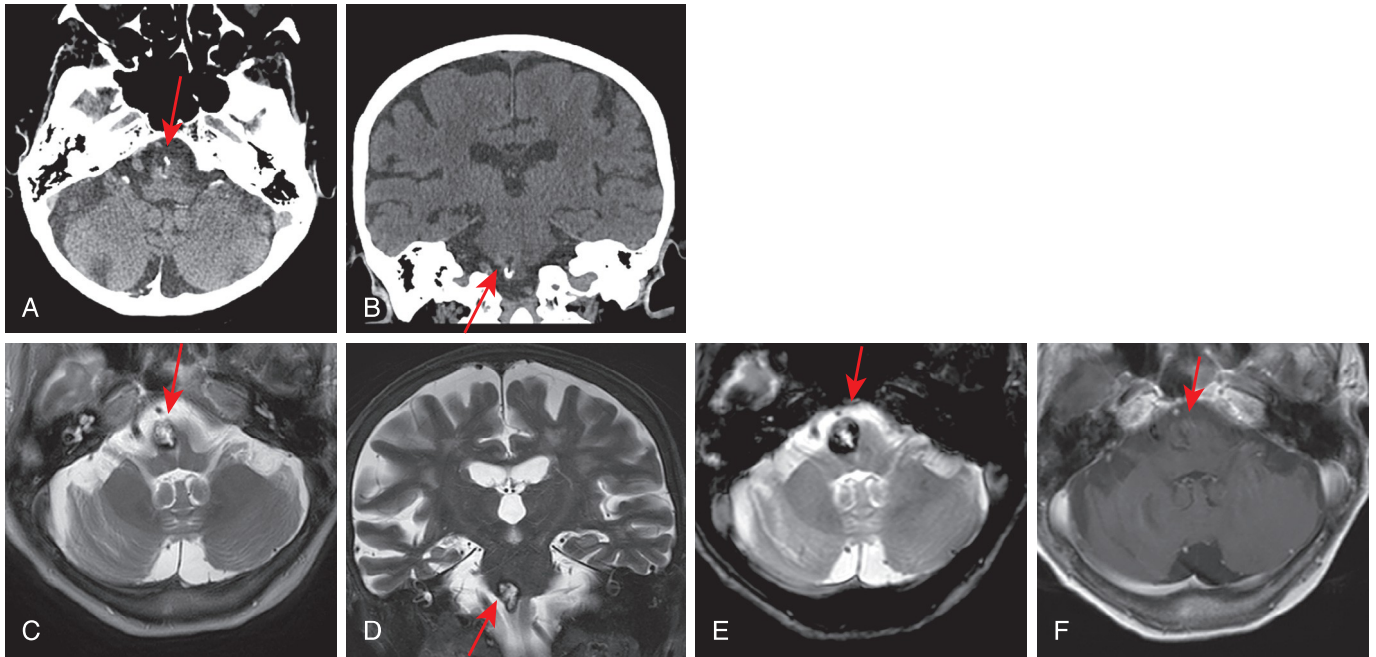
Cavernous malformation. An 84-year-old woman presented with altered mental status. Axial (A) and coronal (B) noncontrast head computed tomography images demonstrate an exophytic partially calcified lesion centered in the region of the right medullary olive (red arrows). Axial T2 (C) coronal T2 (D), axial gradient echo (E), and axial T1 postcontrast (F) images confirm the presence of an exophytic right medullary cavernous malformation with a characteristic “popcorn” appearance, complete peripheral rim of T2 hypointensity, susceptibility blooming, and faint enhancement (arrows).
